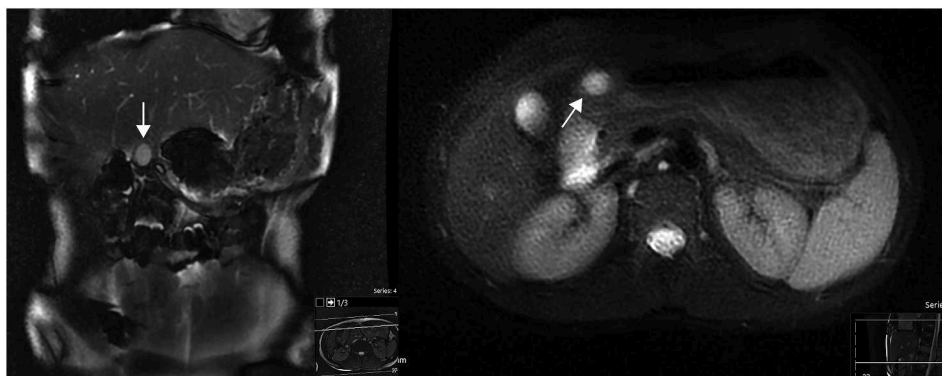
Preoperative MRI of patient 3 (Arrow: Tumor).
